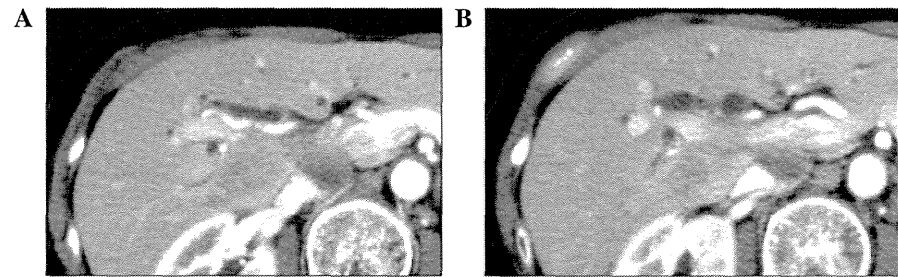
Changes after chemotherapy (A) in the gallbladder tumor and (B) in terms of neural invasion, shown by computed tomography imaging. (A) A clear reduction in size and decreased invasion was observed in the right hepatic artery. (B) Decreased perineural invasion of the common hepatic and celiac arteries was observed.
